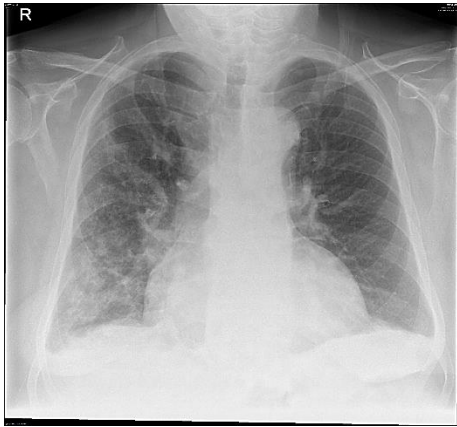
Chest X-ray on discharge.
